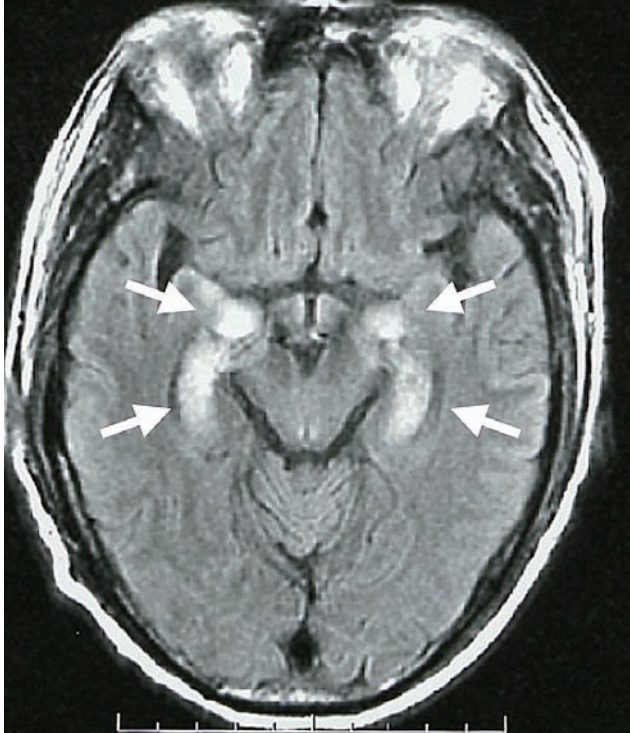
T2-weighted fluid-attenuated inversion recovery imaging in a patient who developed human herpesvirus 6 encephalitis. Arrows indicate signal hyperintensities in the region of the limbic system. Taken from [Reference 65].
